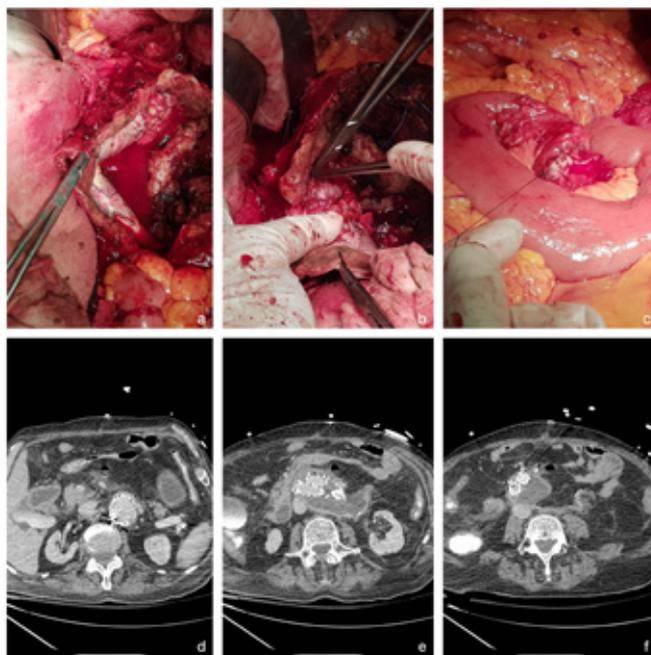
1<sup>st</sup> case, a,b,c: Preoperative CTA d,e,f: CTA 23 days postoperative
